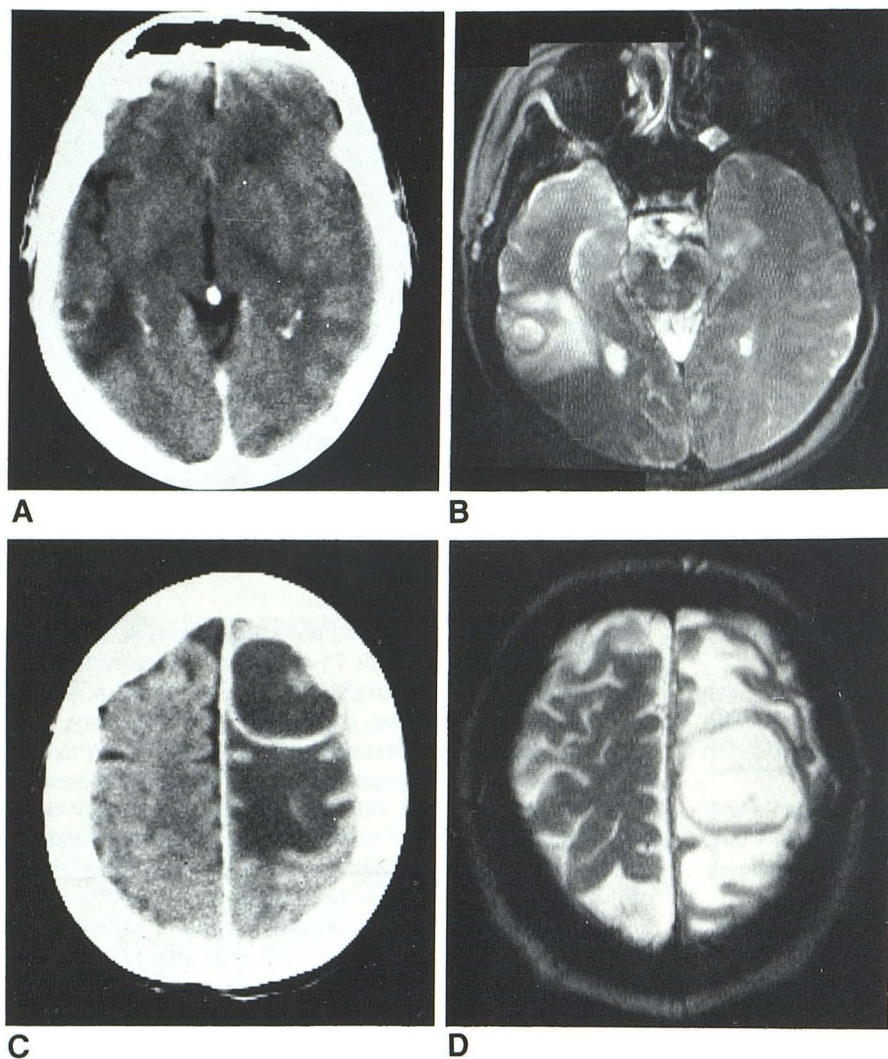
52-year-old man with bronchogenic carcinoma. Two lesions seen with CT, three with MR. A, CT scan. Rim of enhancement adjacent to temporal bone surrounded by edema. B, SE scan, 120 msec TE, 2 sec TR, four buffers, 1.5 T. Lesion in A has rim of decreased signal surrounded by area of increased signal from edema. C, CT scan. Frontal metastatic lesion with rim of enhancement surrounded by edema. D, SE scan, 120 msec TE, 2 sec TR, four buffers, 1.5 T. Lesion corresponds to lesion in C. Tumor and edema can be clearly differentiated. CT was performed with 20° angulation and MR at 0° to orbitomeatal lines. This is why lesion appears at different locations in the two images.
